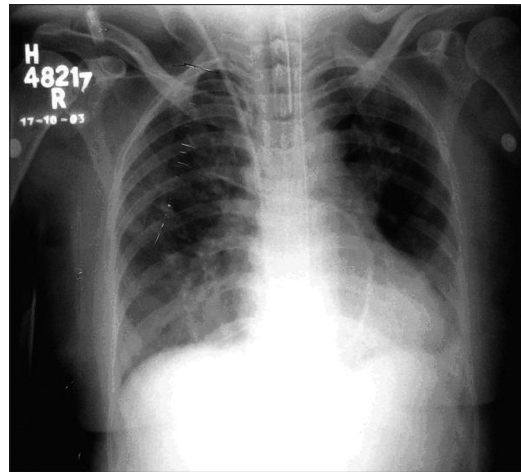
Chest radiograph showing resolution of pulmonary oedema with treatment. X-ray shows pulmonary artery catheter in place
